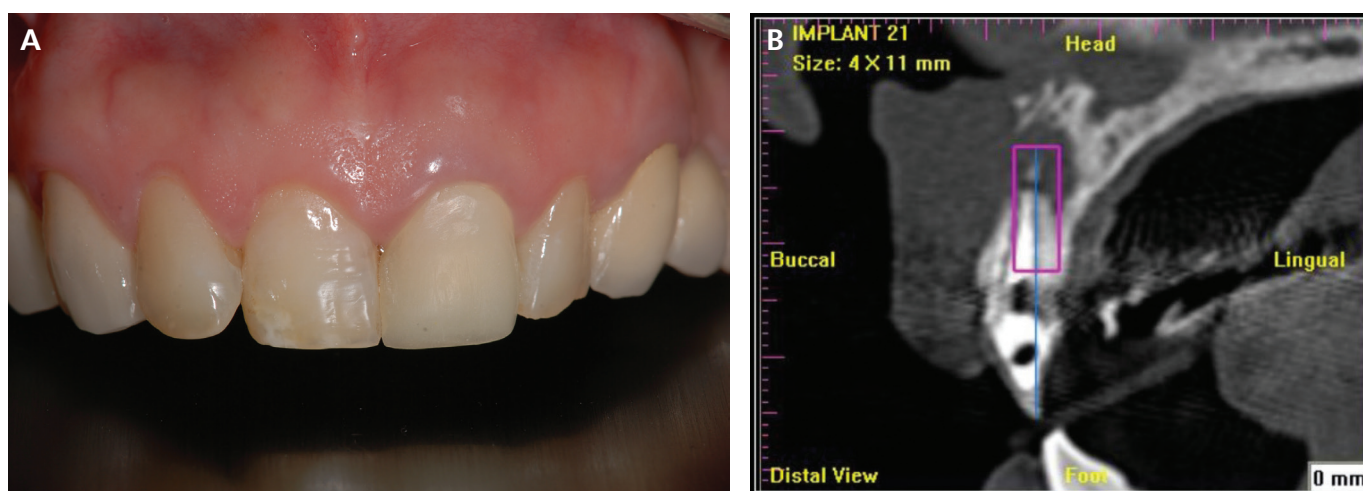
(a) Provisional crown on maxillary left central incisorPt, (b) CT image showed a large periapical lesion.
